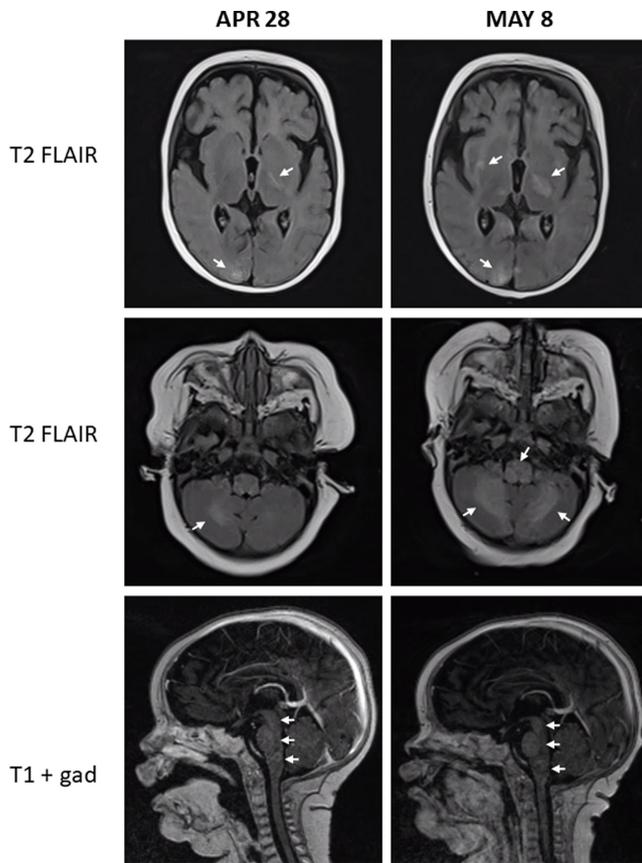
CNS-HLH manifestations. Serial MRI images of the brain demonstrate progressive white matter lesions (indicated by arrows) in the cerebral hemispheres, cerebellum and brain stem, compatible with HLH-associated CNS inflammation. CNS, central nervous system; HLH, hemophagocytic lymphohistiocytosis; gad, gadolinium contrast
